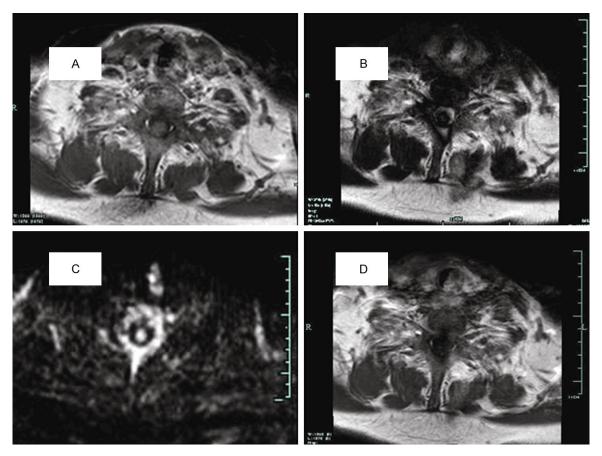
MRI of neck revealed that a $1.0 \text{ cm} \times 2.5 \text{ cm}$ irregular mass in the cervical trachea, approximately 2.5 cm below the glottis. The T1 (A)- and T2 (B)-weighted signals were hyperintense. DWI suggested hyperintense lesions (C), contrast-enhanced T1-weighted images revealed heterogenous enhancement (D).
